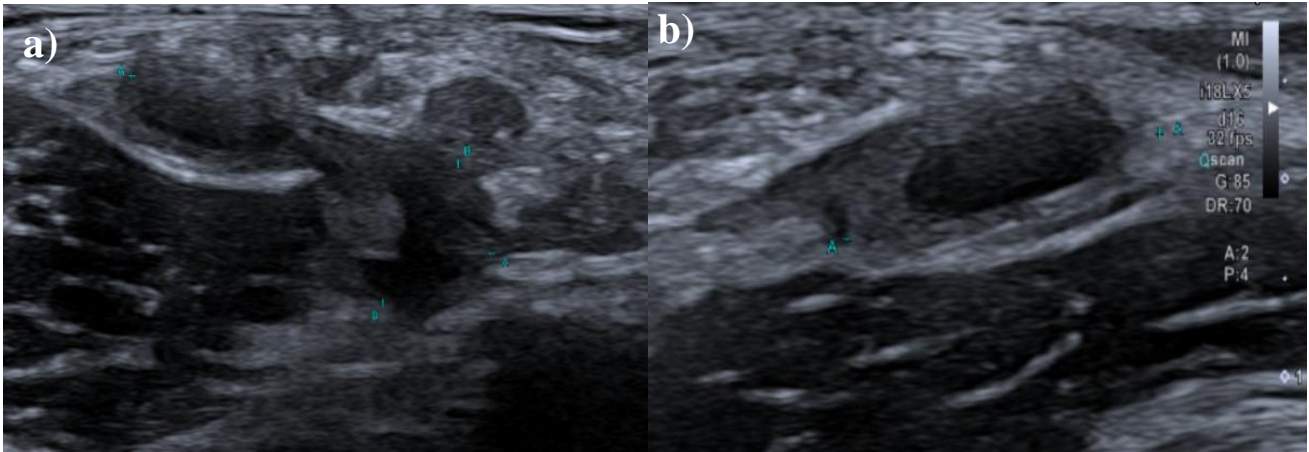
Axial (a) and sagittal (b) ultrasound images of post-treatment of the Baker's cyst within the left popliteal fossa of the 11-month interval. The rest significant reduction in size of the cyst from 1.0cm x 4.0cm x 4.6cm to 0.9 x 1.6 x 1.0 cm, associated with a thickened wall.
